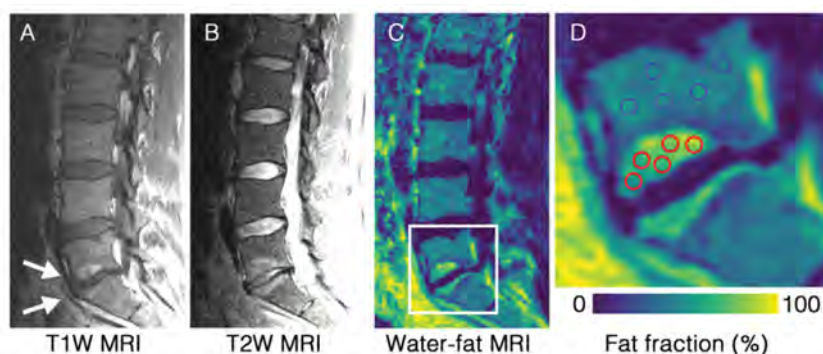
Mid-sagittal images show BMLs (primarily MC II) at L5/S1 on (a) T₁-weighted, (b) fat-saturated T₂-weighted, and (c) water-fat MRI. (d) Inset from water-fat MRI showing ROIs placed in the affected (red) and unaffected (blue) bone marrow. Images from a 37-year-old male patient.
